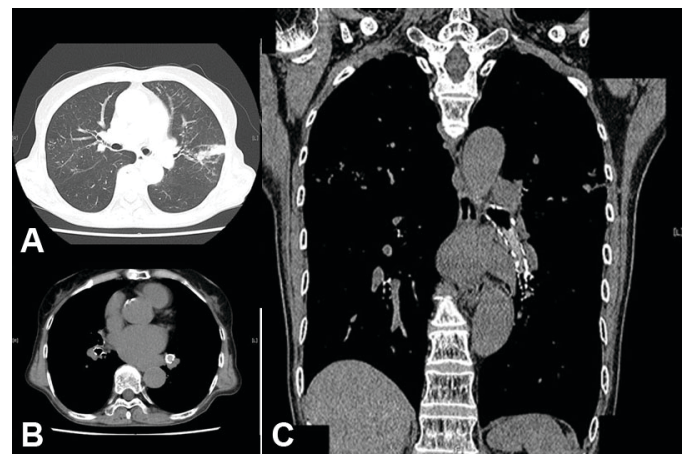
Thoracic CT: Consolidation was observed on left lingual lobe (A). Material within the left main bronchus is purulent on CT [(B) axial and (C) coronal view (C)].
